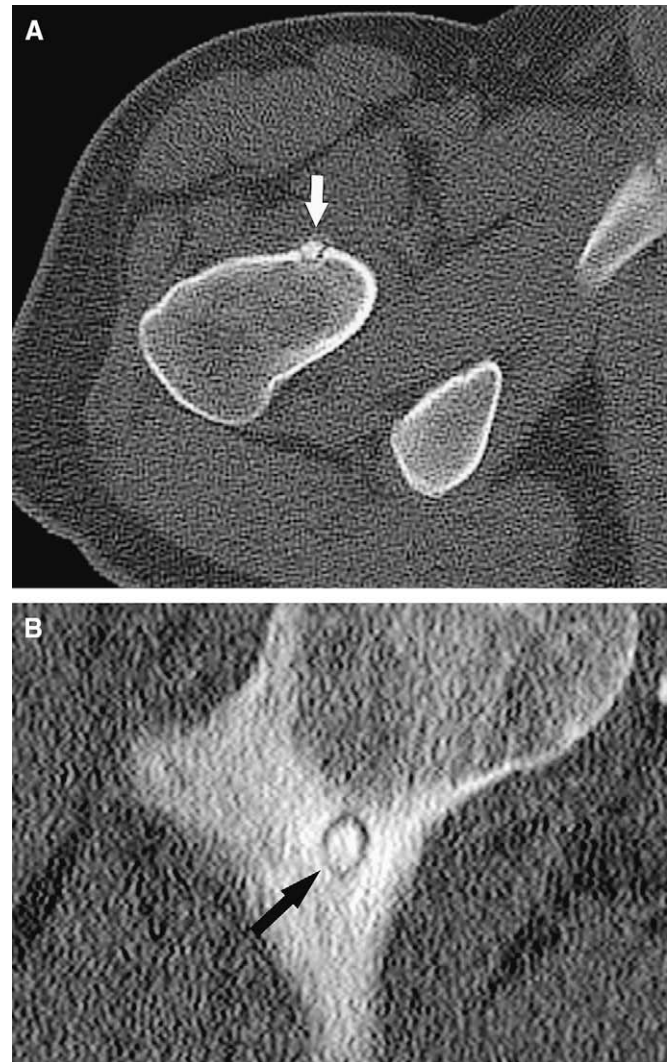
(A) Thin-slice, low-dose computed tomography axial image and (B) coronal reformat localize the lesion to the anterior cortex of the femoral neck. The lesion has a densely mineralized core with a surrounding thin, uniform, lucent rim and lack of periosteal reaction. There is a very thin margin of sclerosis seen in the adjacent cancellous bone.
